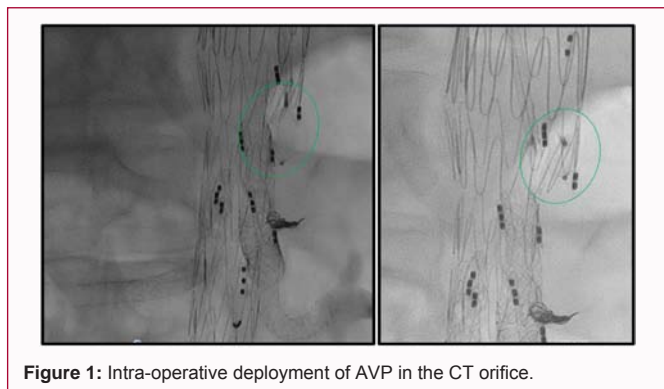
Intra-operative deployment of AVP in the CT orifice.
